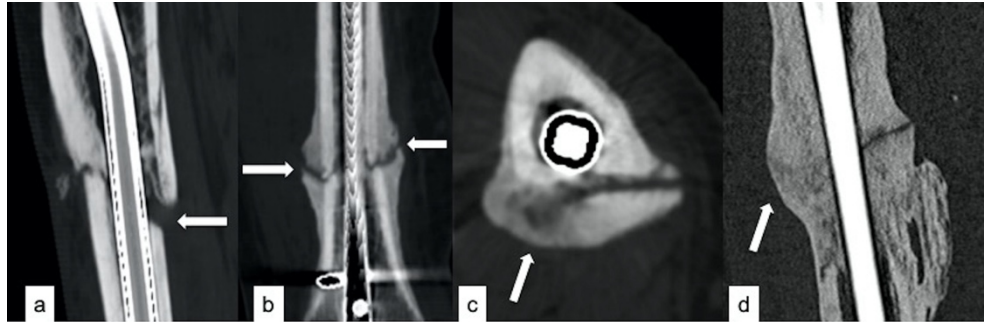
(a) Coronal, (b) sagittal and (c) transverse CT reformats of a nailed non-united tibial fracture in a 55-year-old man. Lateral (#2 and #8), paralateral (#3 and #7), paramedian (#4 and #6) and median (#5) CT reformats were obtained in the three orthogonal planes.
